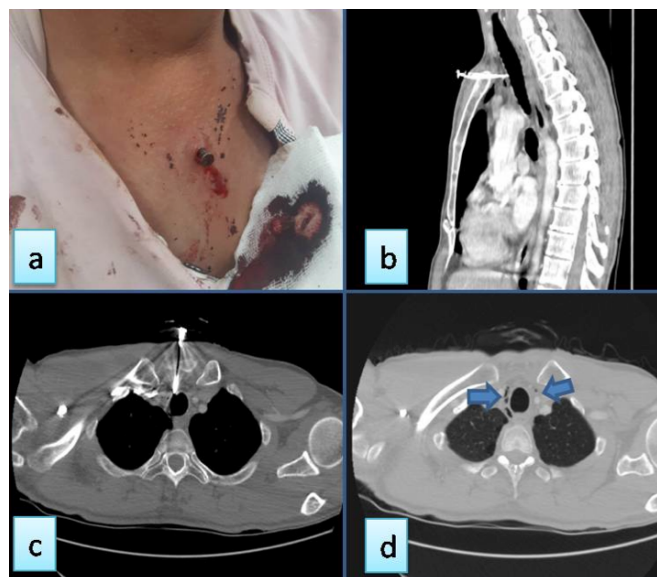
Photography of nail in the sternum of the patient (a), sagittal (b) and axial (c) CT images showing the transsternal localization of the nail and minimal pneumomediastinum (d) (arrows).
